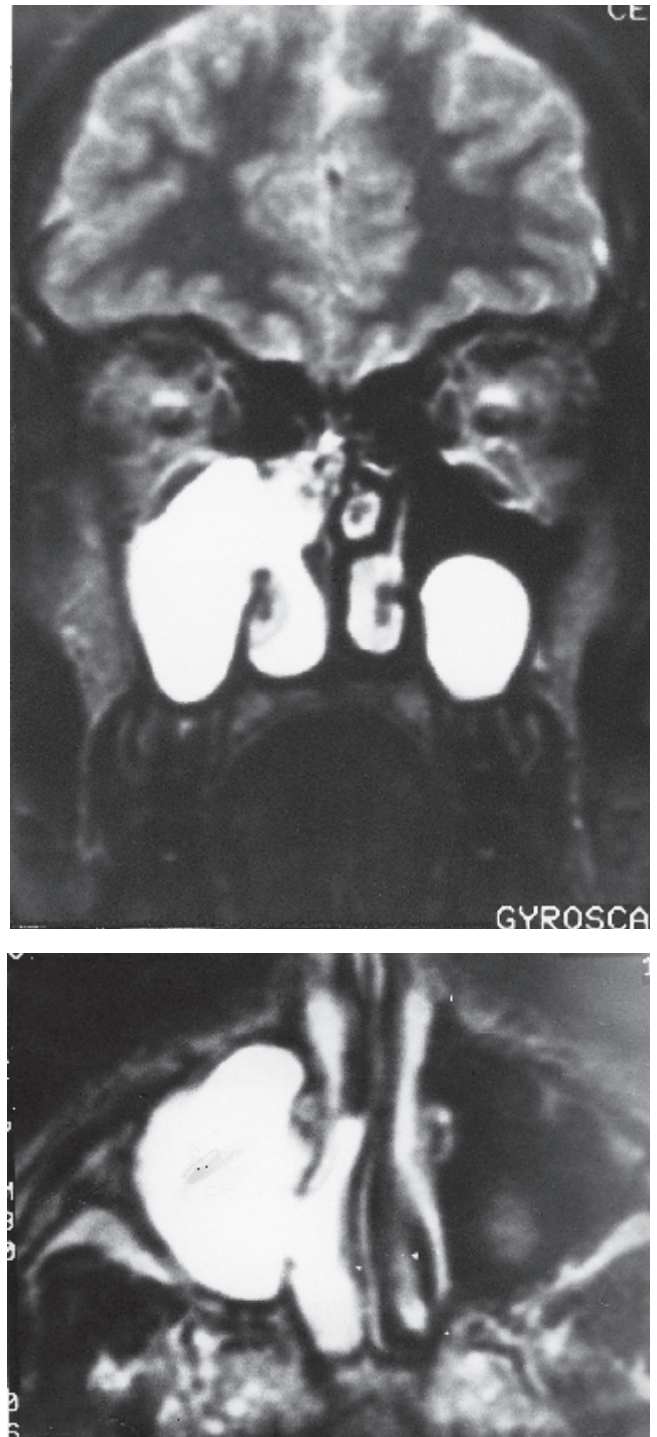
Coronal (a) and axial (b) T<sub>2</sub>-weighted MR images from a 22-year-old male patient: ACP originating from a cyst of the right maxillary sinus. A smaller cyst is seen in the left maxillary sinus.
